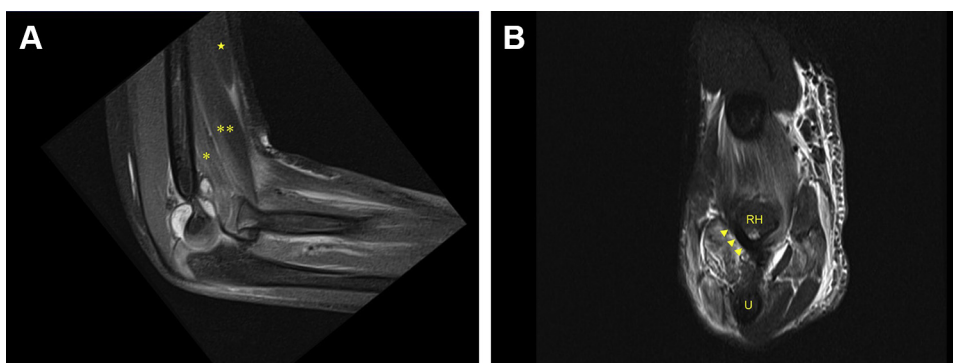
(A) Sagittal magnetic resonance image of the *Right* elbow showing the dislocated radial head, biceps muscle (star), superficial head of the brachialis muscle (double asterisks), and deep head of the brachialis muscle (single asterisk). The superficial head of the brachialis tendon is wrapped around the radial head, and the brachialis tendon acts as a suspensory sling. (B) Coronal magnetic resonance image of the *Left* elbow showing the dislocated radial head (RH) anterior to the ulnar bone (U). Note that the radial head is buttonholed through the brachialis muscle. The superficial head of the brachialis tendon is wrapped around the radial head (arrow heads).
